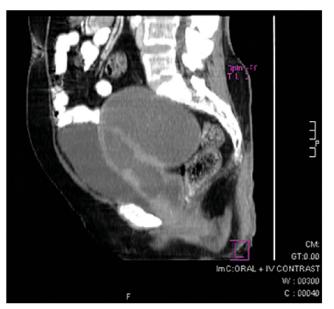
CT showing haematometra and haematocolpos. (Courtesy: Dr Parveen Gulati, New Delhi.)
